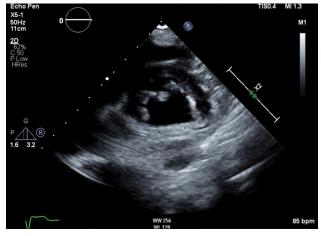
Parasternal short-axis 2D view from TTE showing mitral valve systolic phase with prominent anterior mitral leaflet and absent posterior leaflet.
